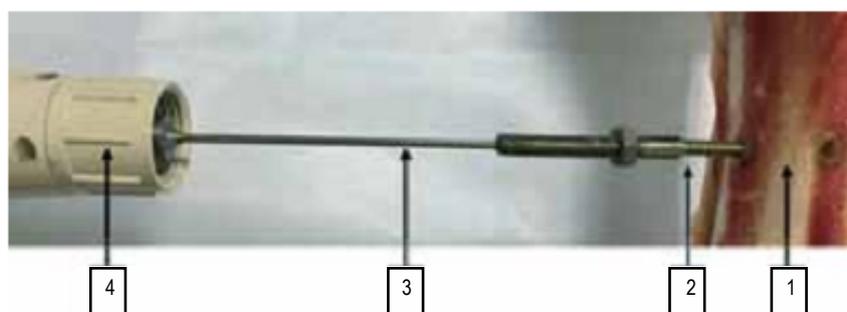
Introduction of ultrasonic tool to hollow rod-screws.
